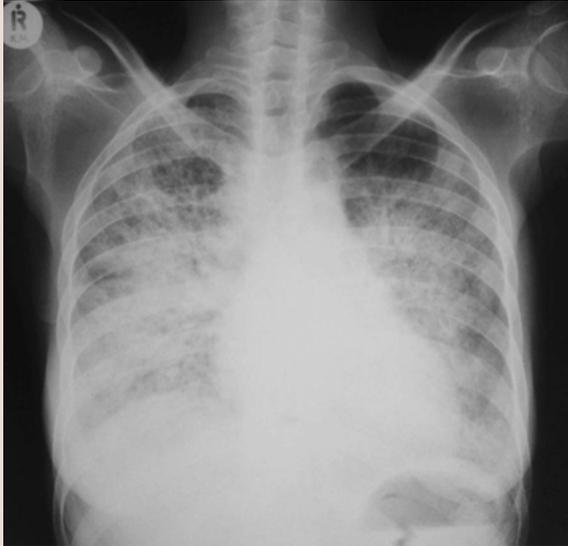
Chest X-ray of a PCP patient, showing a ground-glass appearance, especially in the central lung areas.
